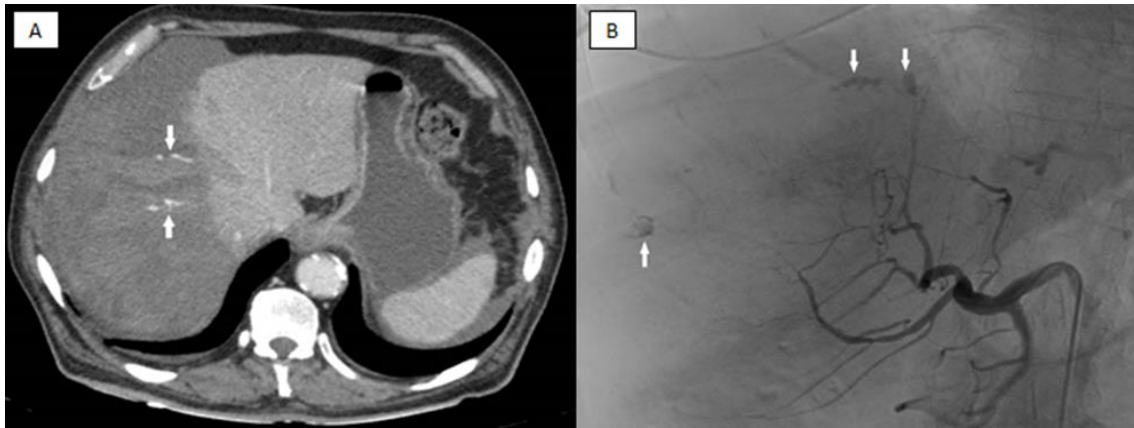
A. Abdominal computed tomography. Voluminous subcapsular hepatic hematoma. Destructuration of the right hepatic lobe. Contrast extravasation suggestive of active arterial bleeding (arrows). B. Arteriography. Active arterial bleeding of distal branches of the right hepatic artery (arrows).
